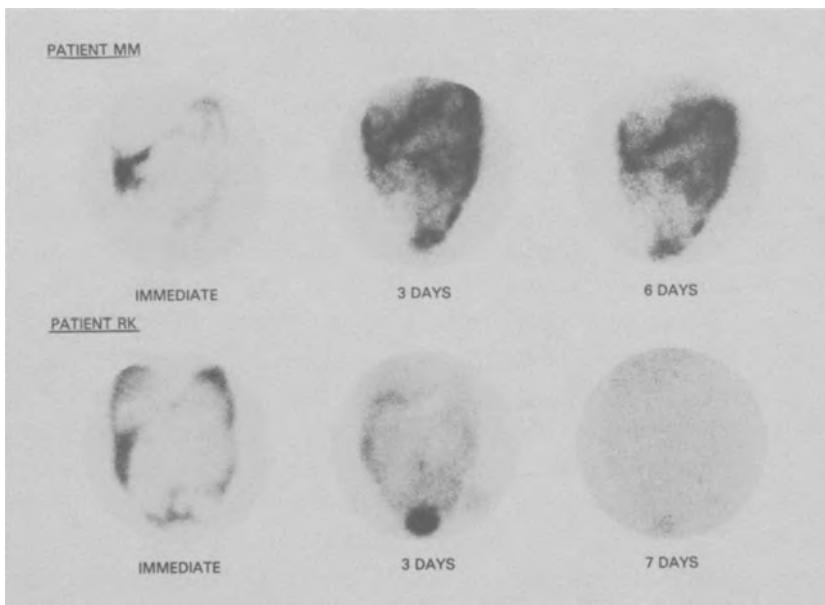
Radioimmunoscintigraphy in patients with metastatic colorectal cancer after ip administration of ^{131}I -B72.3 IgG. Two patients were injected ip with radiolabeled B72.3 IgG. Patients RK and MM were scanned immediately after antibody administration and at various times, as indicated in the Fig. Patient RK, with no peritoneal tumor, was negative for B72.3 localization, whereas the peritoneal tumor was visualized by B72.3 in patient MM. Taken from Colcher et al., 1987b.
